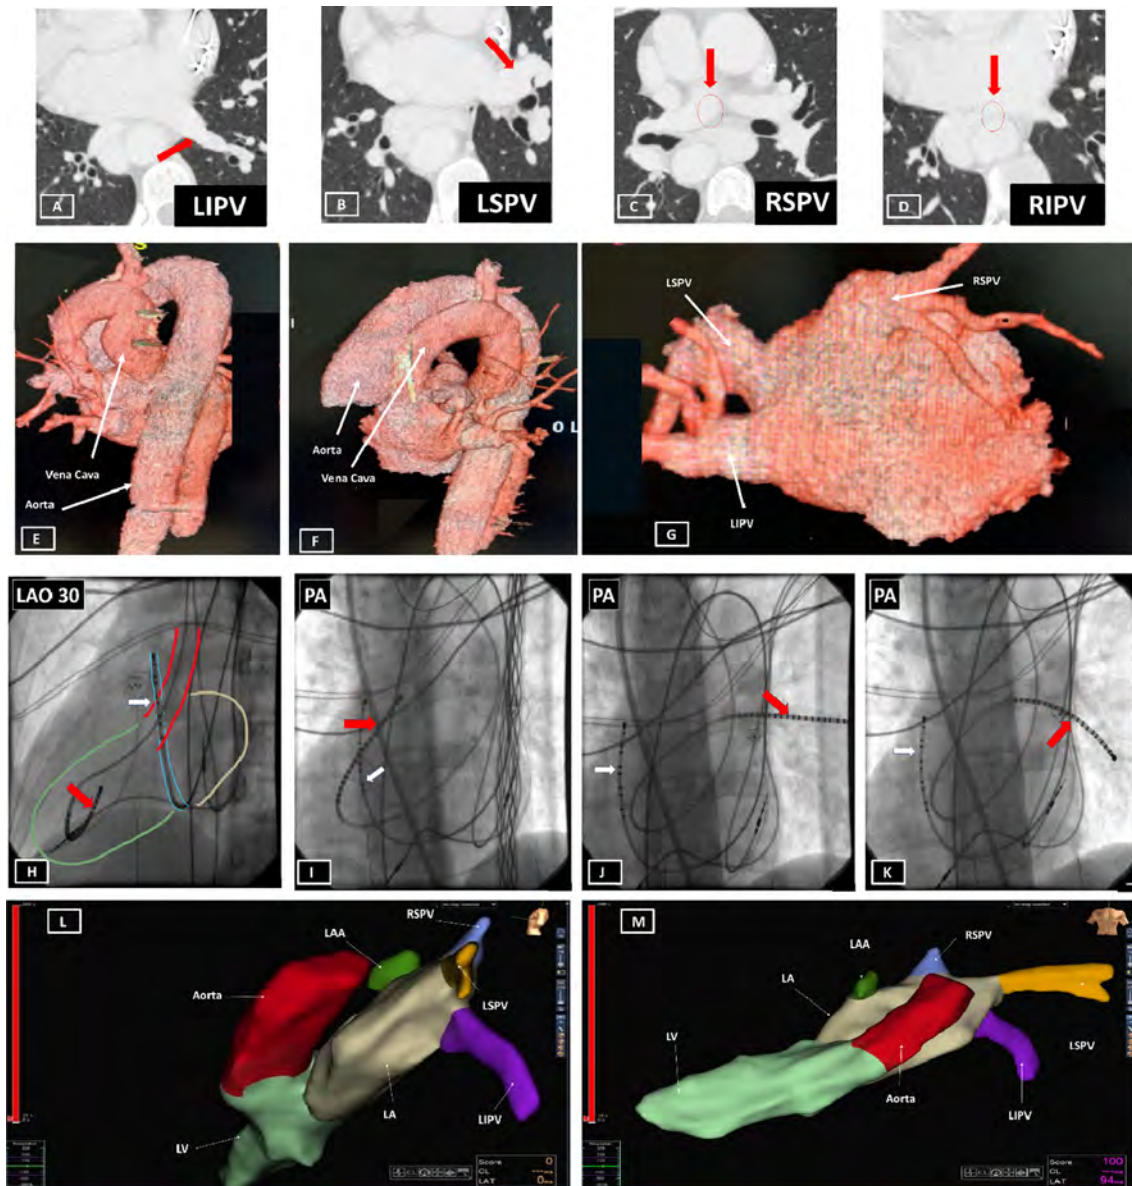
Computed tomography image of the (A) left inferior pulmonary vein, (B) left superior pulmonary vein, (C) very small and posterior right inferior pulmonary vein, (D) big right superior pulmonary vein with cranially entrance in the left atrium. 3D reconstruction of the aorta, inferior vena cava (E, F), left atrium and pulmonary veins anatomy (G) obtained from the pre-interventional CT-Imaging. (H–K) Fluoroscopic anteroposterior images showed mapping catheter in the left ventricle (H), right superior pulmonary vein (I), left superior pulmonary vein (J) and left inferior pulmonary vein (K). (L) and (M) present the 3D reconstruction of the aortic root, the left ventricle, the left atrium and the pulmonary veins.
